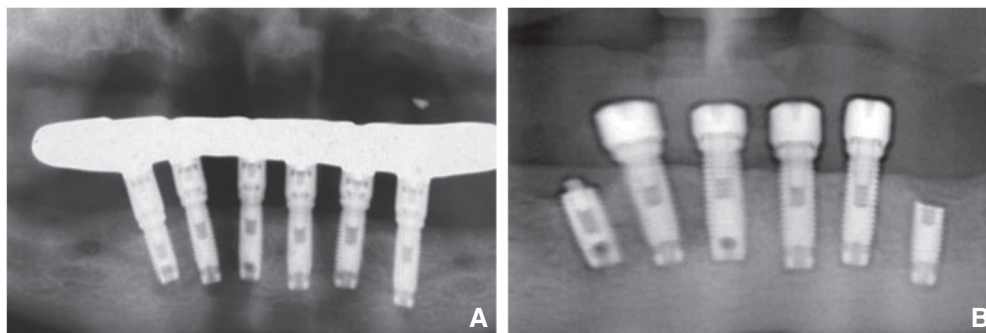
Panoramic radiographs of participant who experienced FOI. A, Fixed implant-supported prosthesis fabricated over 6 implants. B, Two most distal implants supporting fixed complete arch prosthesis fractured. Fractured implants buried, and removable implant-supported prosthesis fabricated instead. FOI, Fracture of osseointegrated implant.
